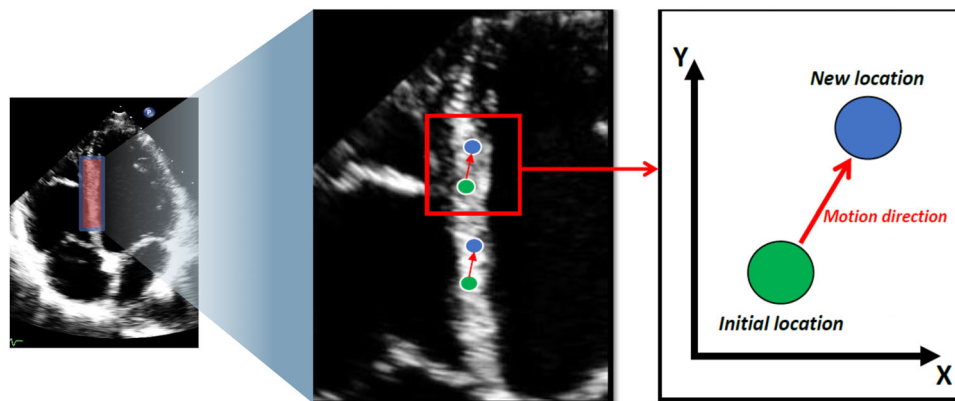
The basic principle of speckle tracking echocardiography. The speckles are identified and tracked frame by frame in a greyscale echocardiographic image. Created in BioRender. Akhmimi, A. (2026) <https://BioRender.com/qgvf7da>.
